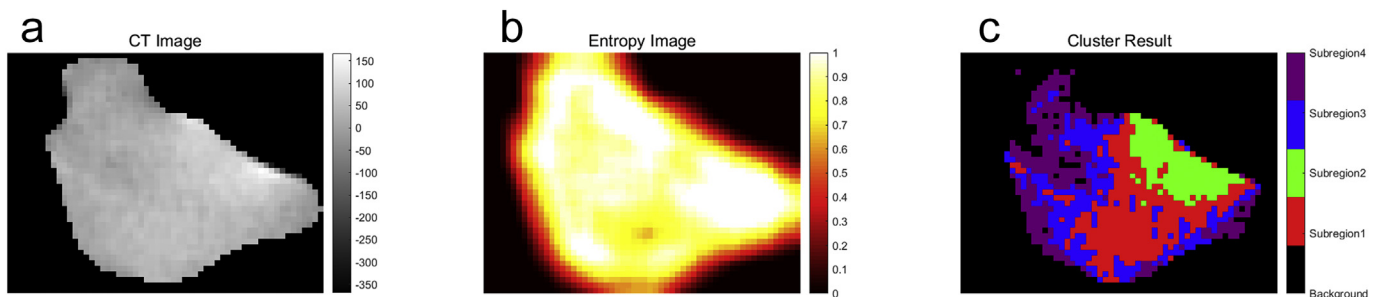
(a) The tumour region in the CT images; (b) The local entropy image. (c) The cluster results.
